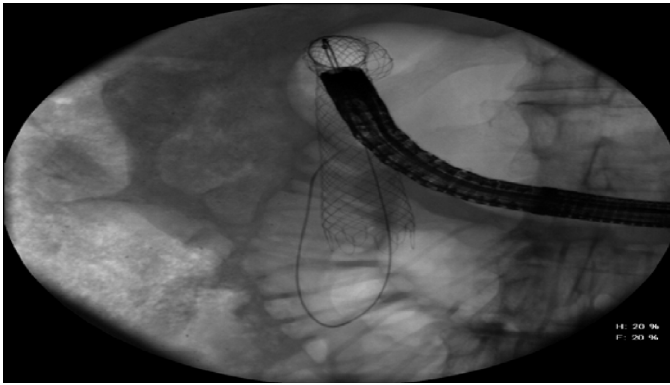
Radiographic view of the guidewire-directed stent placement crossing the duodenal stenosis.
